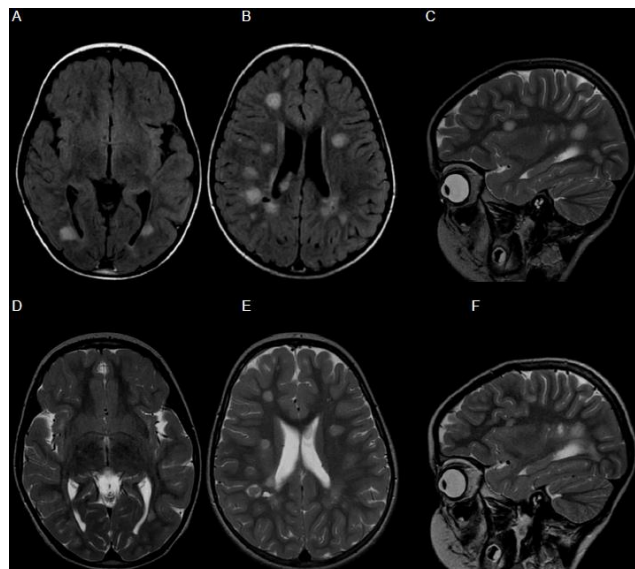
Initial (A-C) and follow-up (D-F) magnetic resonance imaging (MRI) with axial (A, B, D, E) and sagittal planes (C, F): MRI on hospital day one shows disseminated supratentorial hyperintense white matter lesions predominant on the right side (A, B, T2-weighted FLAIR). Occipital lesions, present on both sides, show maximum diameters of 21mm (C, T2 frFSE). Follow-up MRI after five months shows very slight regression of demyelination foci (D-F, T2 frFSE).
